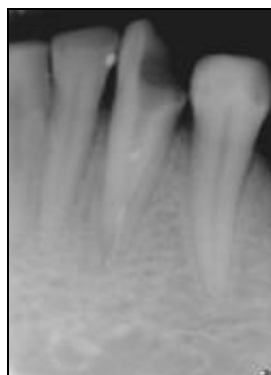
Radiograph showing presence of two roots
